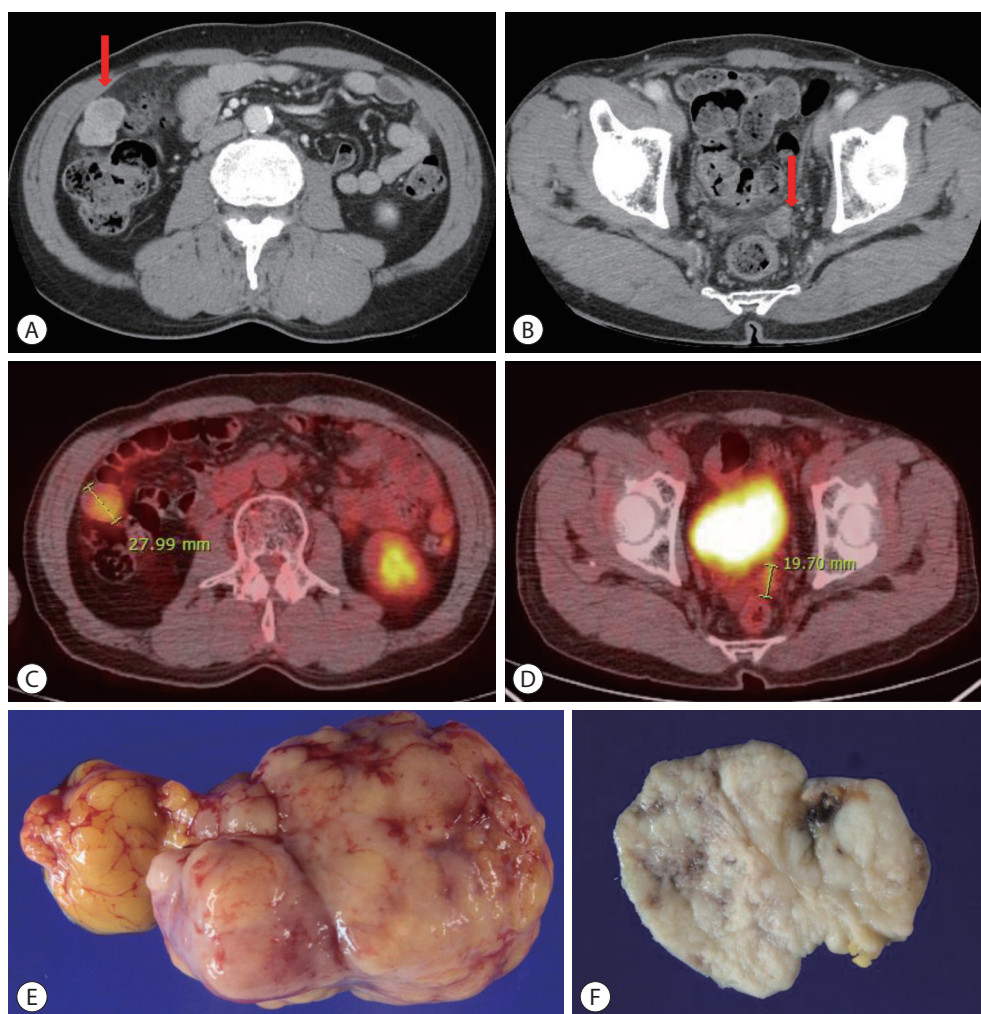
Follow-up liver dynamic computed tomography (CT) and positron emission tomography (PET)/CT imaging findings on May 2017: the progression of peritoneal metastases and omental metastatic mass of hepatocellular carcinoma after surgical resection on June 2017. (A) Liver dynamic CT, arterial phase, right upper quadrant area on abdominal cavity (red arrow). (B) Liver dynamic CT, arterial phase, rectovesical pouch (red arrow). (C) PET/CT, 2.8 cm sized nodule on right upper quadrant area on abdominal cavity. (D) PET/CT, 1.97 cm sized nodule on the rectovesical pouch. (E) Mass on right upper quadrant area on abdominal cavity. (F) Mass on the rectovesical pouch.
